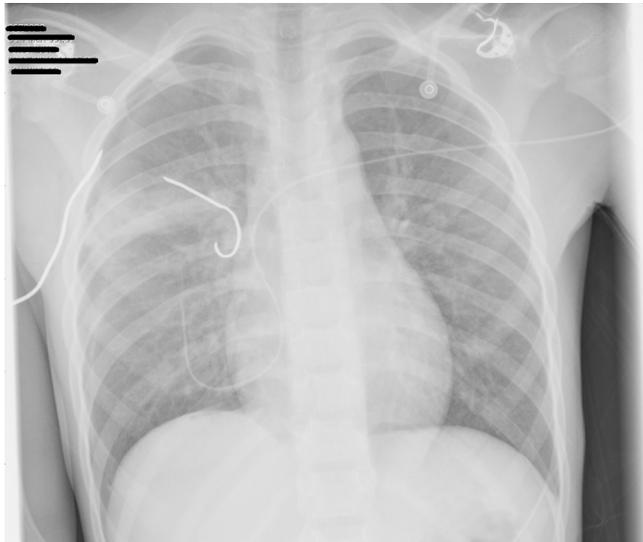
Chest radiograph with “shrapnel” in the right side of the hemithorax.
